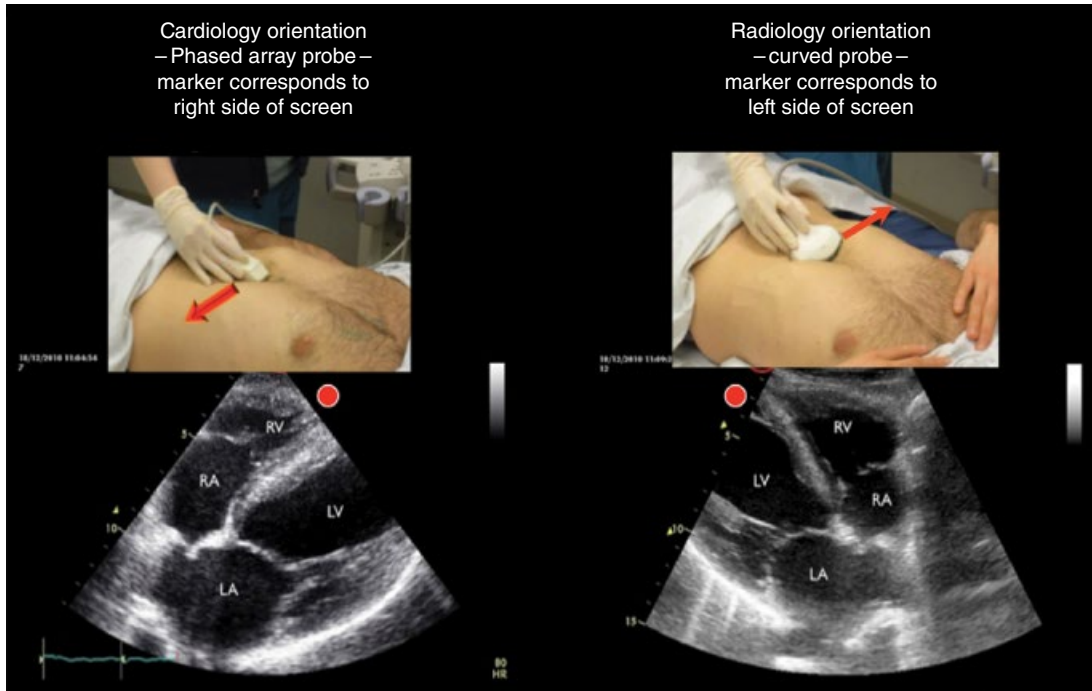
Differences in transducer orientation and image generation in transthoracic echocardiography and general radiology in obtaining a subcostal view. In both cases, the marker points to the left side of the patient's body (arrows). However, the corresponding orientation on the screen is different for the cardiac (left) and general abdominal (right) transducers, resulting in mirror images.
